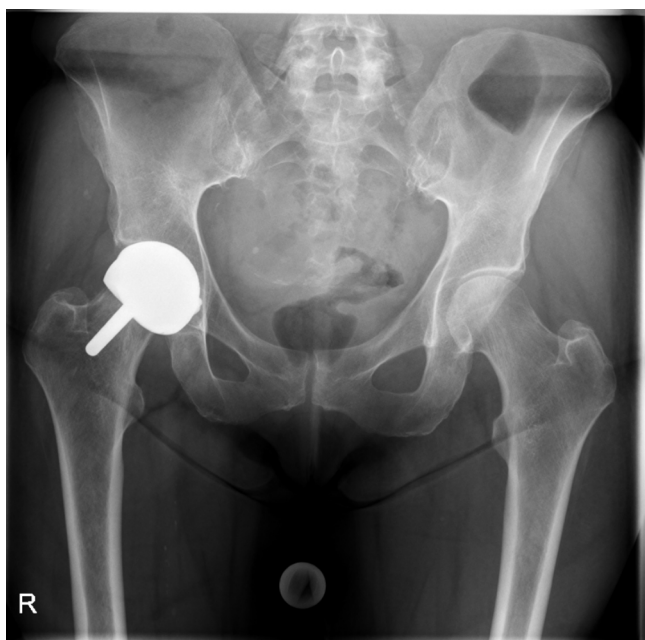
AP pelvic radiograph demonstrating right-sided Birmingham resurfacing prosthesis.
